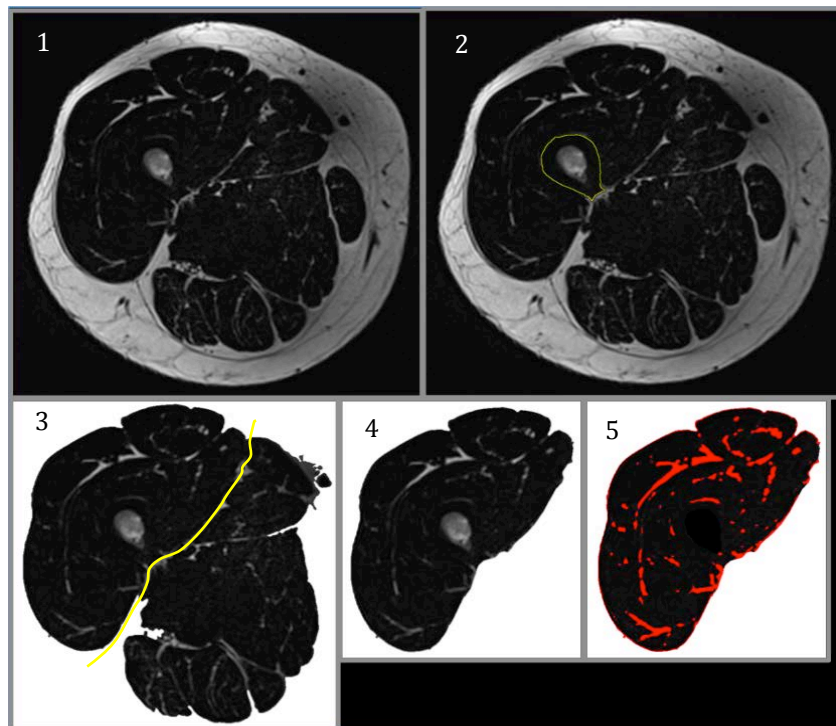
Image series detailing muscle volume determination from an MRI stack
